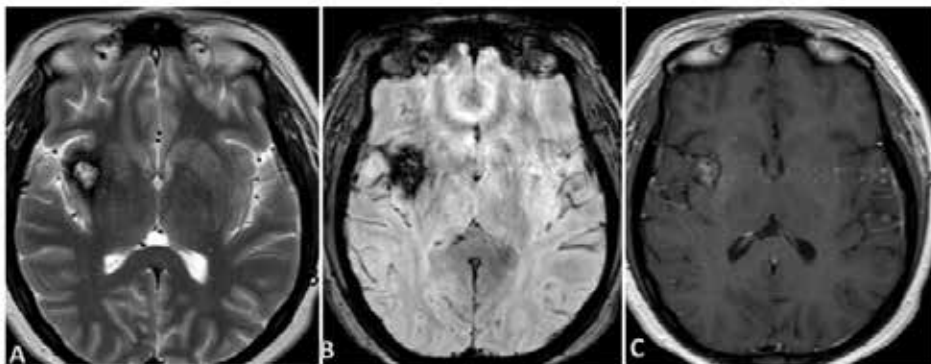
MRI brain shows cavernous malformation involving the right sub insular region, external capsule, and right putamen A. T2 weighted sagittal, B. GRE C. T1 post-contrast images.
